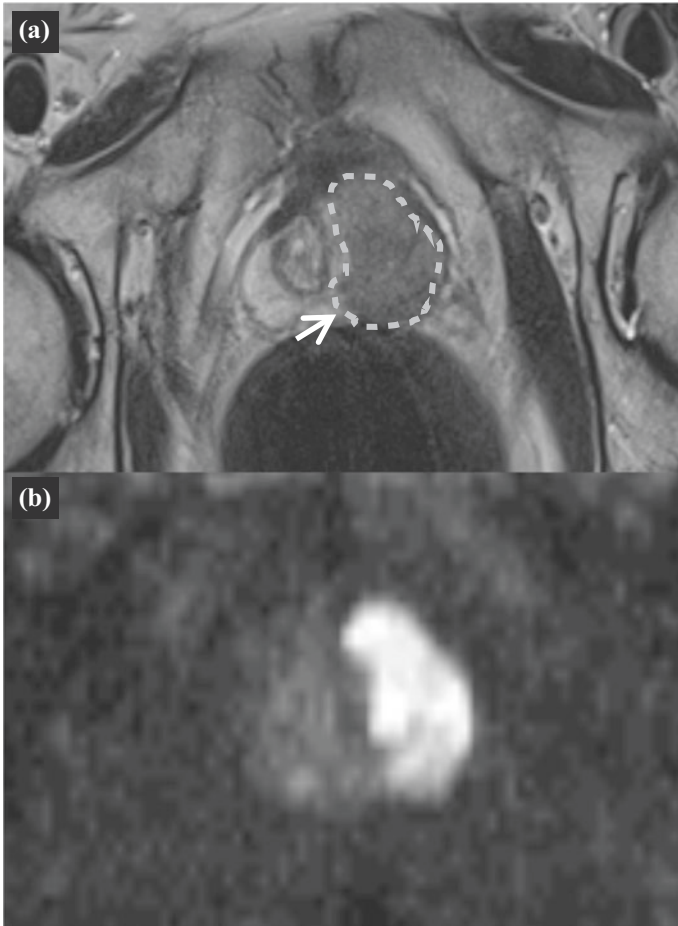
A 55 year old man with family history of prostate cancer was found to have raised serum PSA level of 20 and referred for Prostate MRI. a Axial T2 sequence shows large area of low (dark) signal in left side of gland, with dotted outline. The normal prostate has bright signal on T2 (arrow). b Diffusion weighted images show high signal in the same region, compatible with a large prostate carcinoma replacing the left side of the prostate
